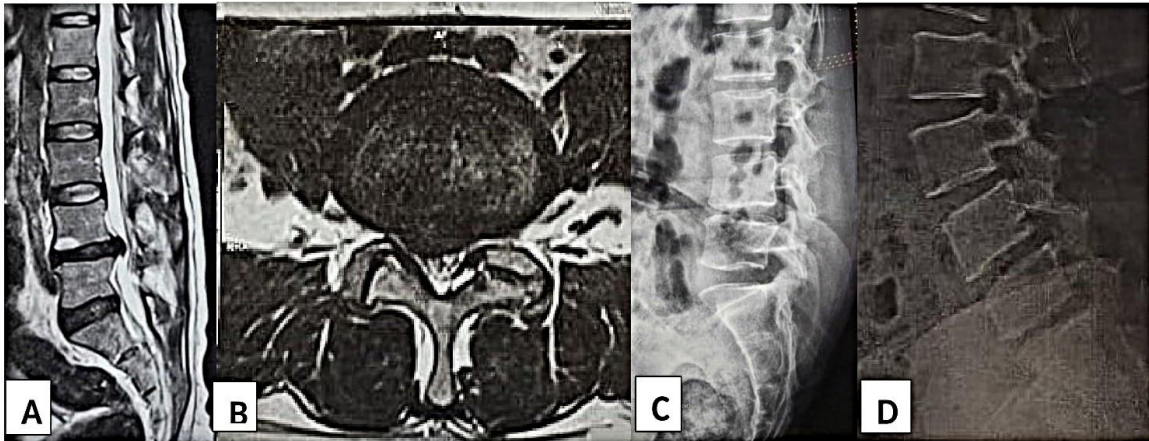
Preoperative images: A. T2 weighted sagittal lumbar MRI showing L4/5 degenerated and herniated disc. B. T2 weighted axial lumbar MRI showing right posterolateral disc herniation and facet tropism. C. Lumbar lateral x-ray in flexion showing L4/5 instability. D. Lumbar lateral x-ray in extension
